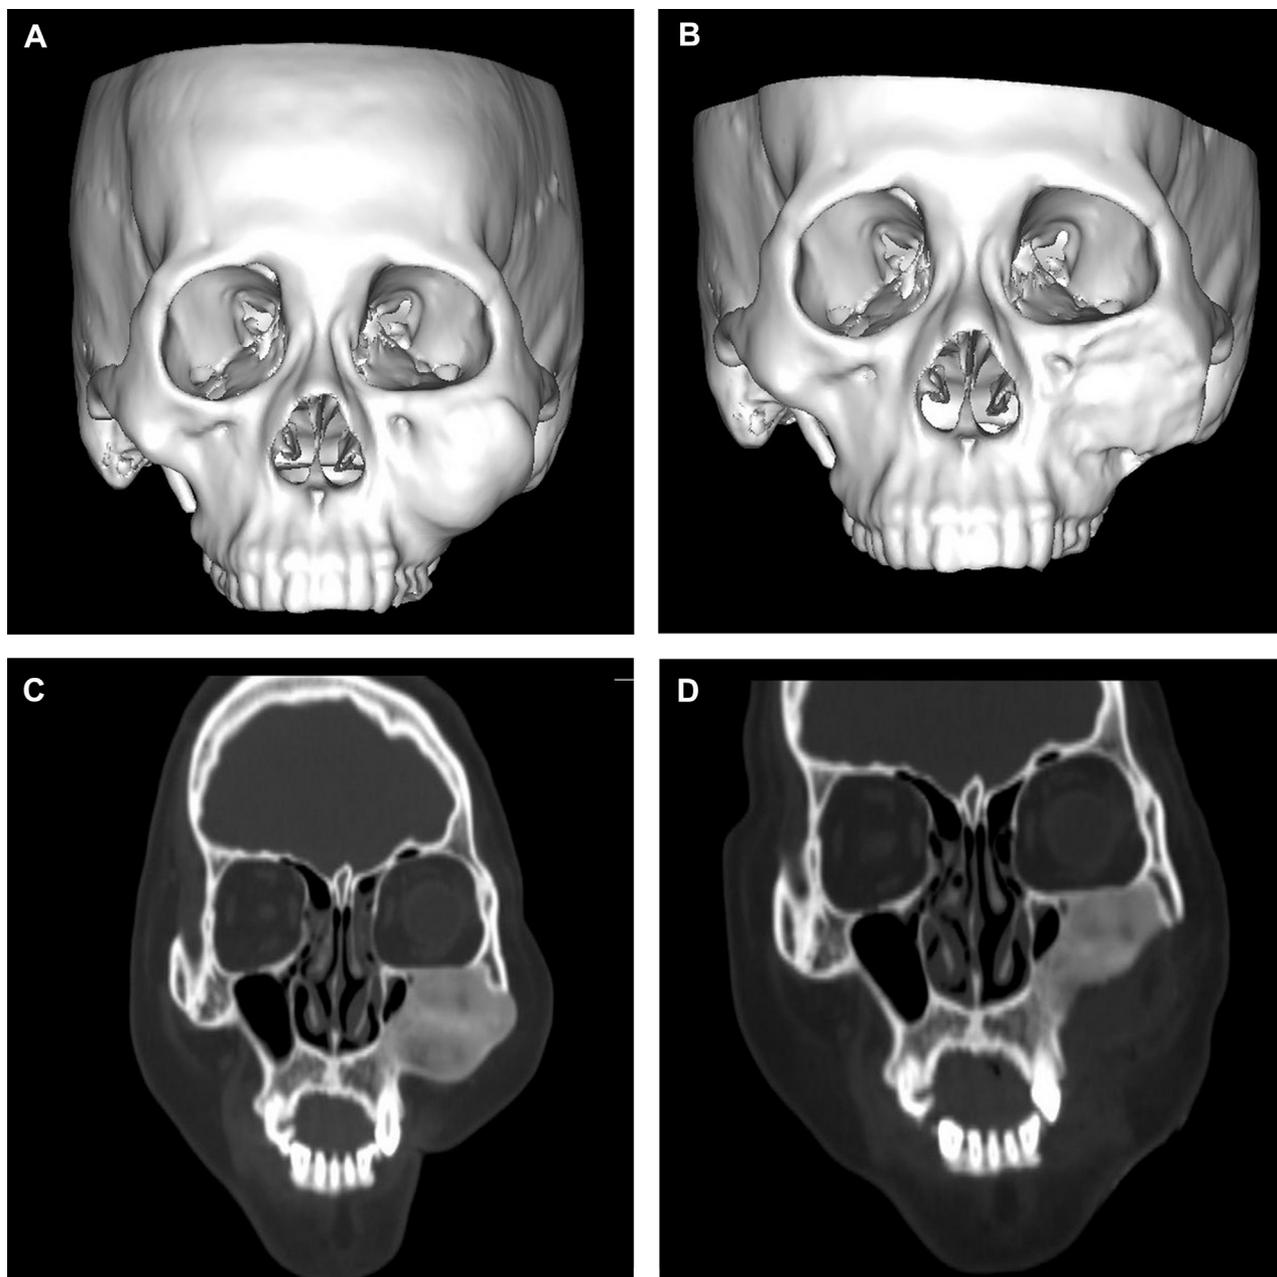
Preoperative (A, C) and postoperative (B, D) CT images. Postoperative CT shows good facial symmetry. CT, computed tomography. Liu et al. Bone Contouring Surgery for Zygomaticomaxillary FD. J Oral Maxillofac Surg 2020.
